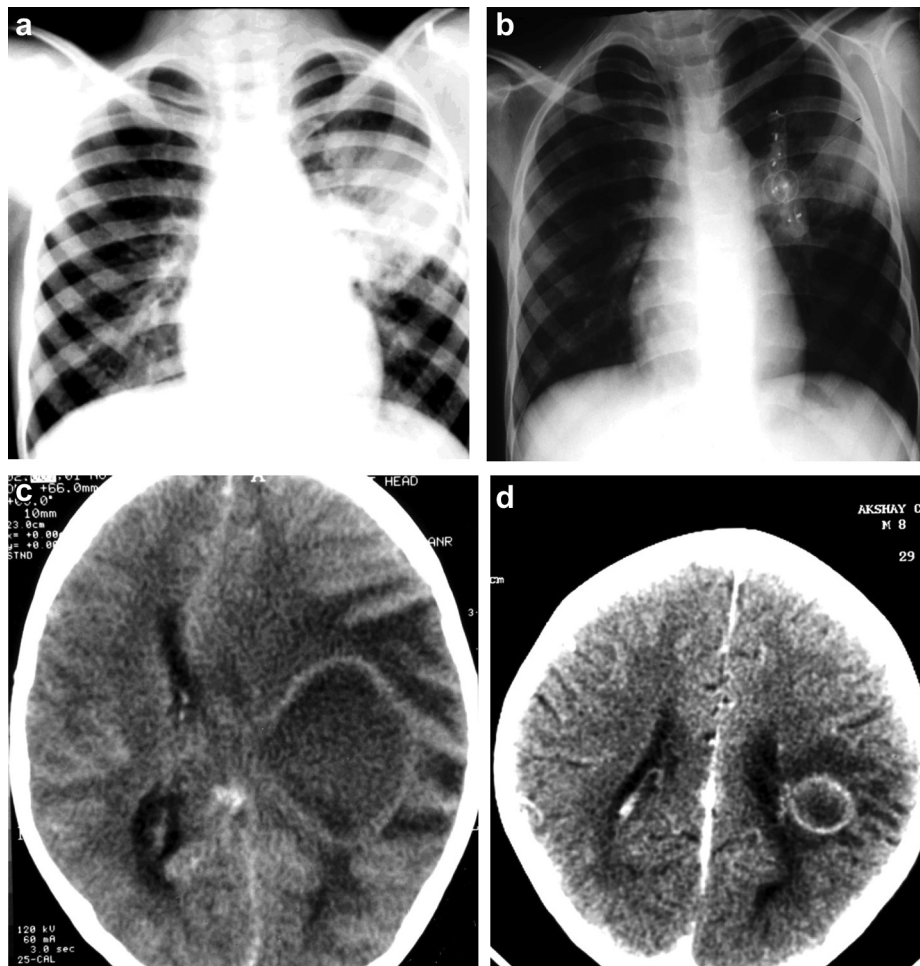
a. CT chest of large PAVM in left upper lobe. b. Angiographic image of post device closure of fistulae with AVP I plugs. c. Left parietal-occipital abscess on CT head. d. CT head after surgery and antibiotics.
